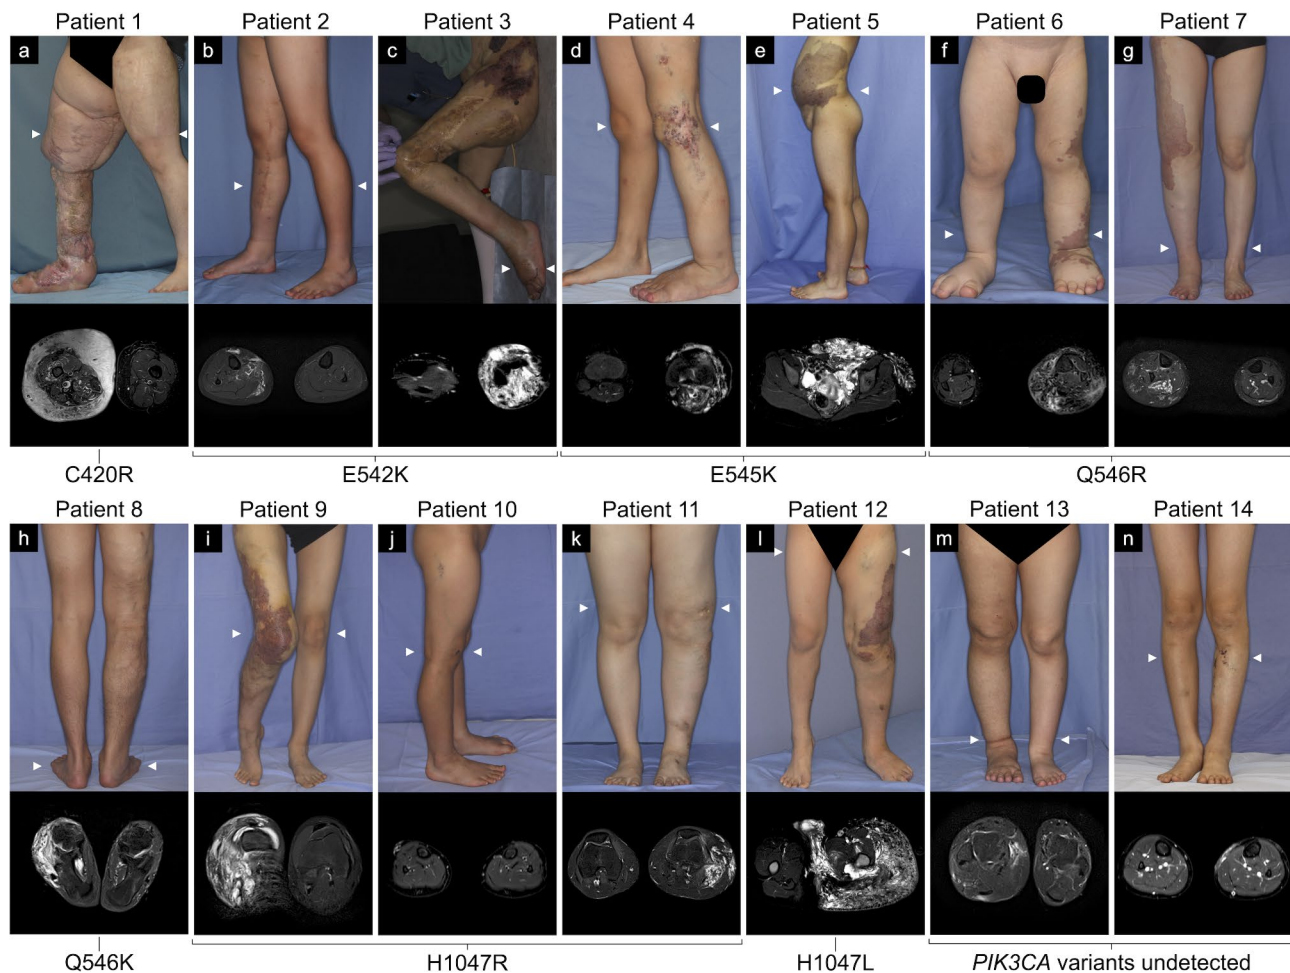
Clinical photographs (upper) and short-tau inversion recovery or fat-suppressed T2-weighted magnetic resonance images (lower) of the patients with Klippel-Trenaunay syndrome with detected or undetected *PIK3CA* variants. Various clinical manifestations were observed, including geographic capillary malformations (a, c-g, i, l), lower limb discrepancy in terms of length (c, d, f, g, i, l, m), and macrodactyly (a, c, d, f, l). Magnetic resonance images are axial views at the arrowhead position in each clinical photograph with the lesions of high signal intensity
